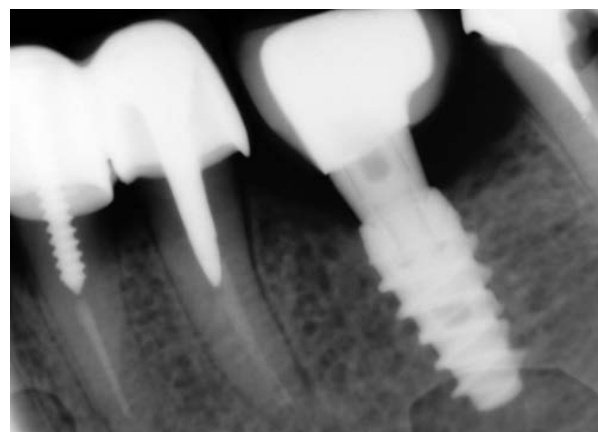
Radiographic image taken after 6 months
